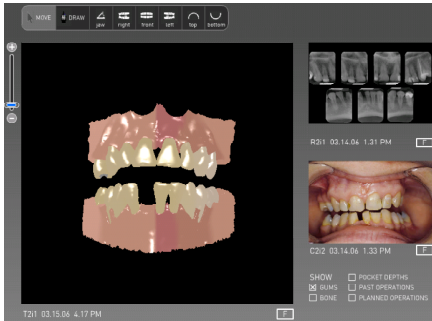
Enhanced retrieval of relevant images by synchronizing views between 3D (left) and 2D radiographs and photographs (right).
